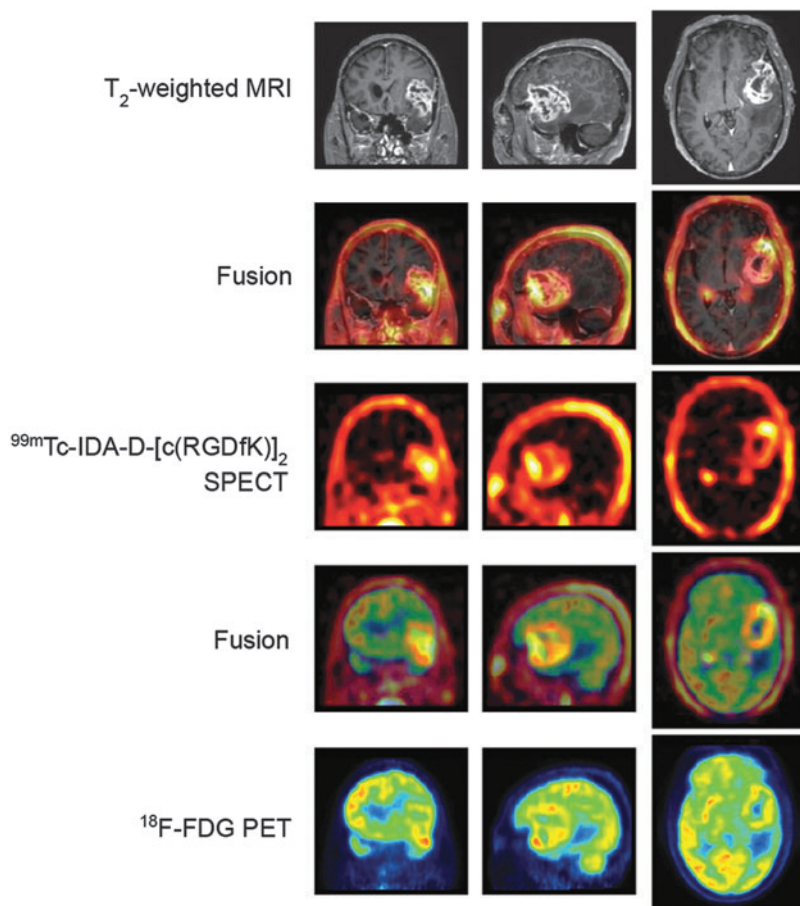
SPECT and ^{18}F -FDG PET images for a patient with brain glioblastoma. Tumor angiogenesis and tumor metabolism are well visualized on ^{99m}Tc -IDA-D-[c(RGDfK)]₂ SPECT and ^{18}F -FDG PET images, respectively. Tumor localization corresponds across all images.
